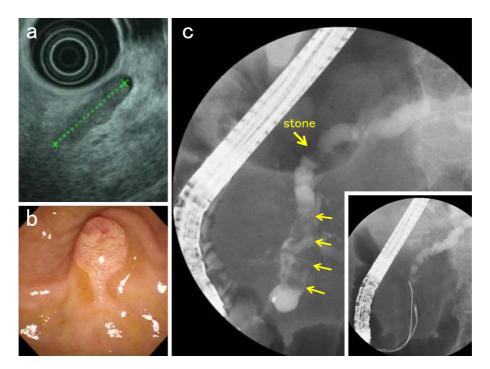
EUS imaging shows a homogeneous hypoechoic mass, 28 mm in length, that fills the MPD of the head of the pancreas. However, no invasion to the adjacent pancreatic parenchyma is evident (a). The appearance of the papilla of Vater is normal, without a dilated ampullary orifice or mucin extrusion (b). ERCP shows a tumor (4 arrows) occupying the cephalic MPD and a stone (arrow) as a filling defect in the dilated MPD (c). During ERCP, a transpapillary forceps biopsy under guidewire assistance was successfully performed (c, inset). EUS: endoscopic ultrasonography, MPD: main pancreatic duct, ERCP: endoscopic retrograde cholangiopancreatography
